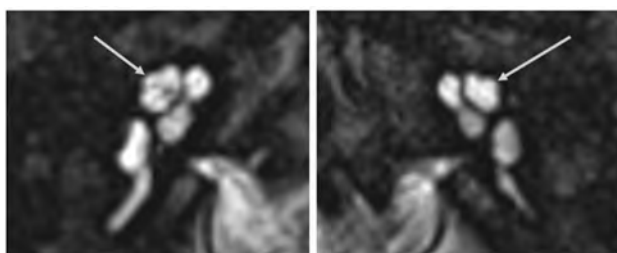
High-resolution 3D heavily T2-weighted MR images of the inner ear and IAC in a patient with a *ZNF699* gene mutation. The uppermost turn of the cochlear apex following the middle turn has a short and stumpy shape (arrows).
